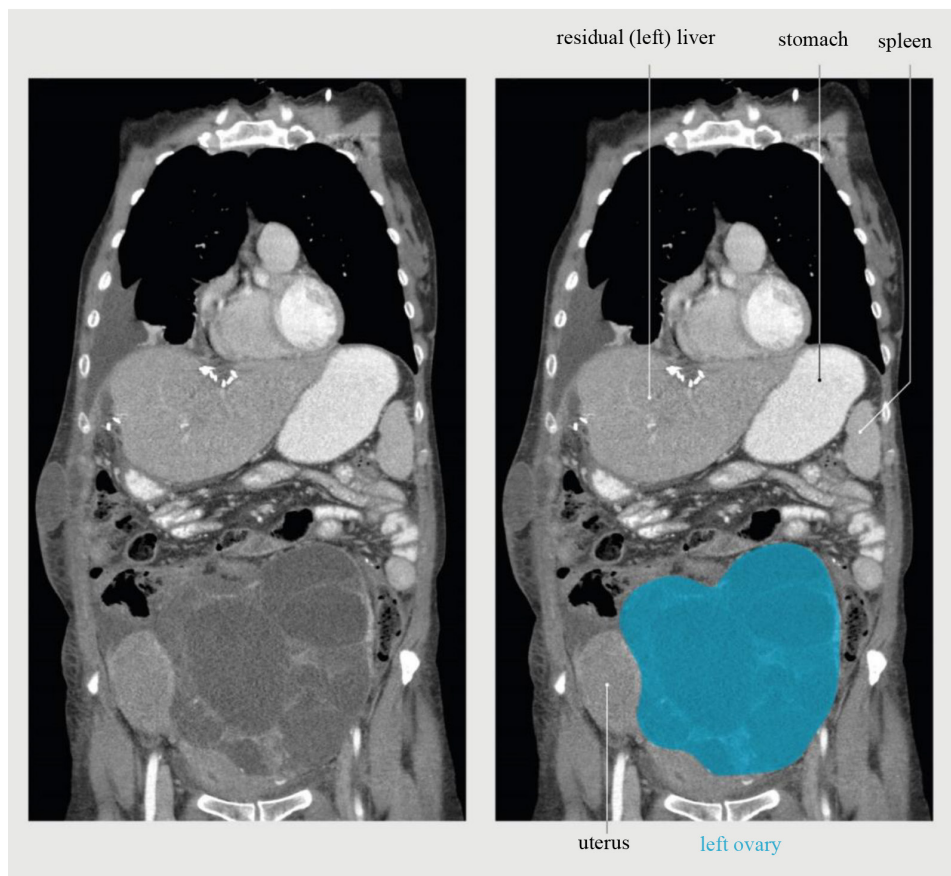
Ovarian malignancy. Coronal view of the CT scan of the thorax and abdomen of a 57-year-old woman treated for lymphatic- and hepatic-metastasized sigmoid carcinoma, stage pT4N1M1. A multilocular mass is observed in the left side of the lesser pelvis, and this mass has the appearance of an ovarian malignancy
